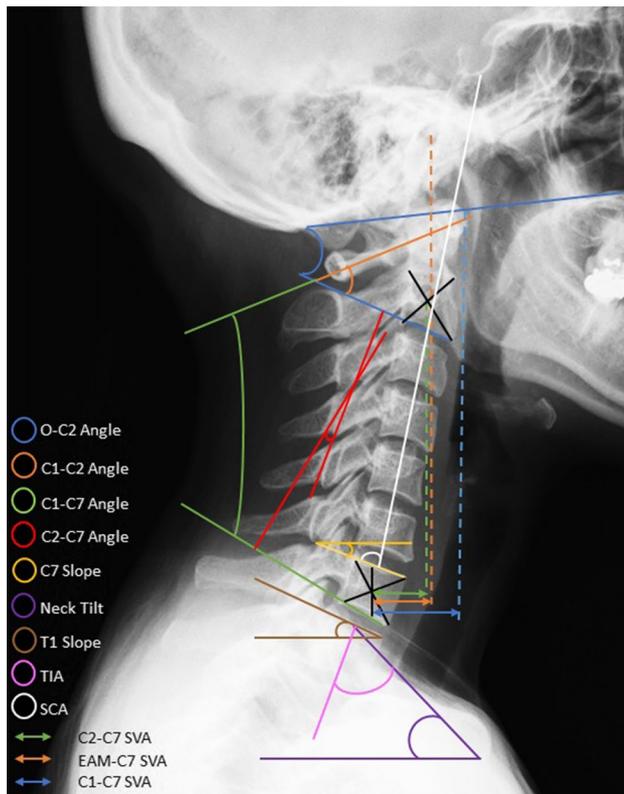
Measured variables of the study in the lateral cervical X-ray
